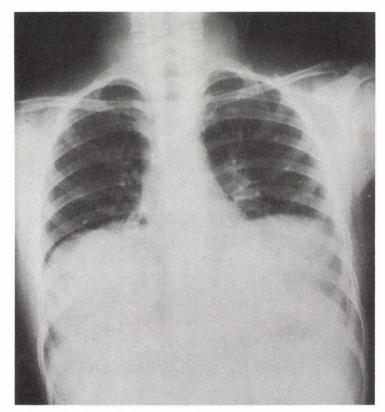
P-A X-Ray: bilateral unruptured cyst.
